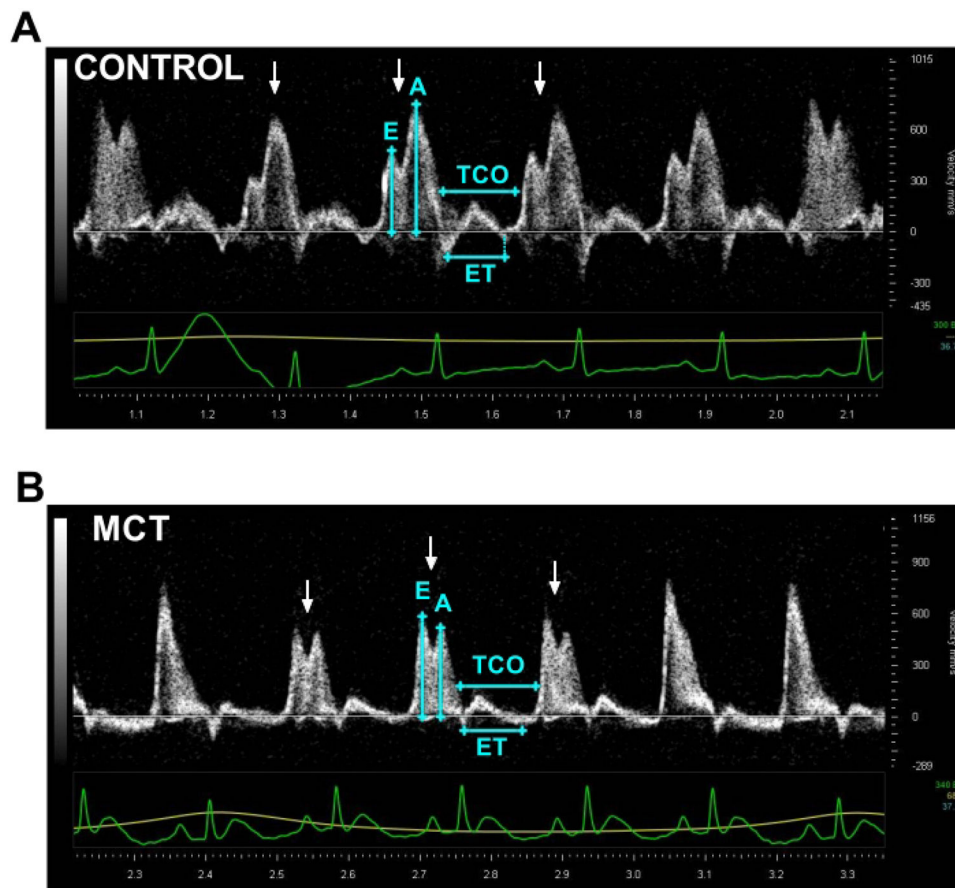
Pulsed wave Doppler of tricuspid inflow.
